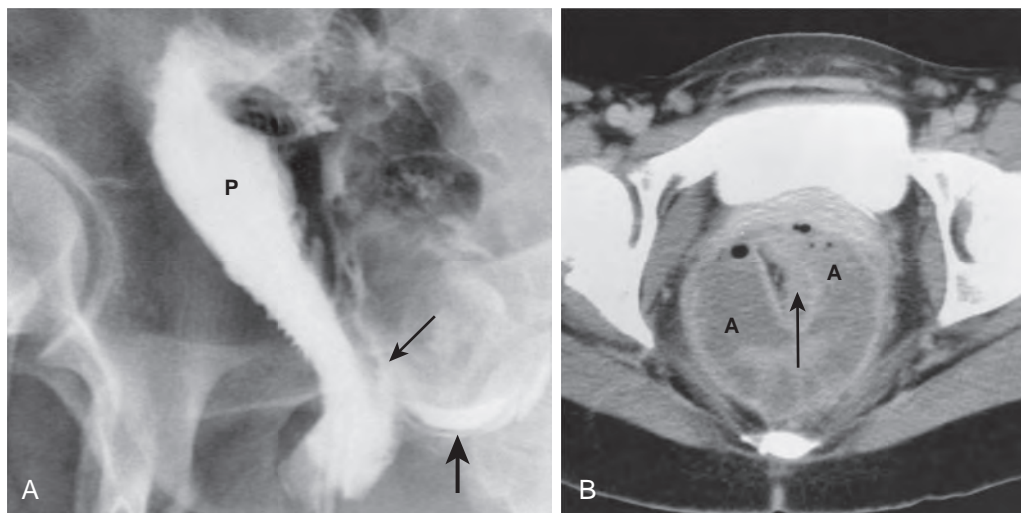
Peripouch abscess. A. J pouch ileogram demonstrates an anastomotic breakdown (thin arrow) with extravasation of water-soluble contrast media (thick arrow). Adjacent pelvic inflammation results in lumen narrowing and irregularity of the pouch (P). B. CT image defines a large multilocular abscess (A) that encircles the collapsed pouch and its fat density mesentery (arrow). Inflammation creates rectal wall thickening and stranding into the perirectal fat. (From Lappas JC, Maglinte DD: *Imaging of the postsurgical small bowel*. *Radiol Clin North Am* 41:305–326, 2003.)
